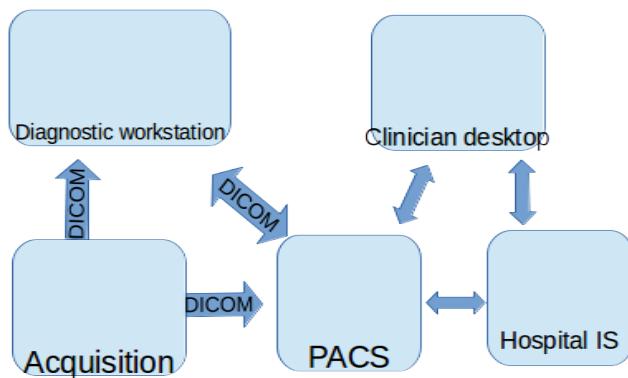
Typical workflow of medical image in hospital. Data acquisition is made by modalities (magnetic resonance, ultrasonography, X-ray radiography, etc.) and using DICOM format and protocol it can be directly transferred and visualized by diagnostic workstation. With metadata filled by an expert physician the image is stored in PACS. Other desktops within hospital can retrieve the image and review the report. The hospital information system may be involved in other workflows and communicate with other formats and standards (HL7,...).
